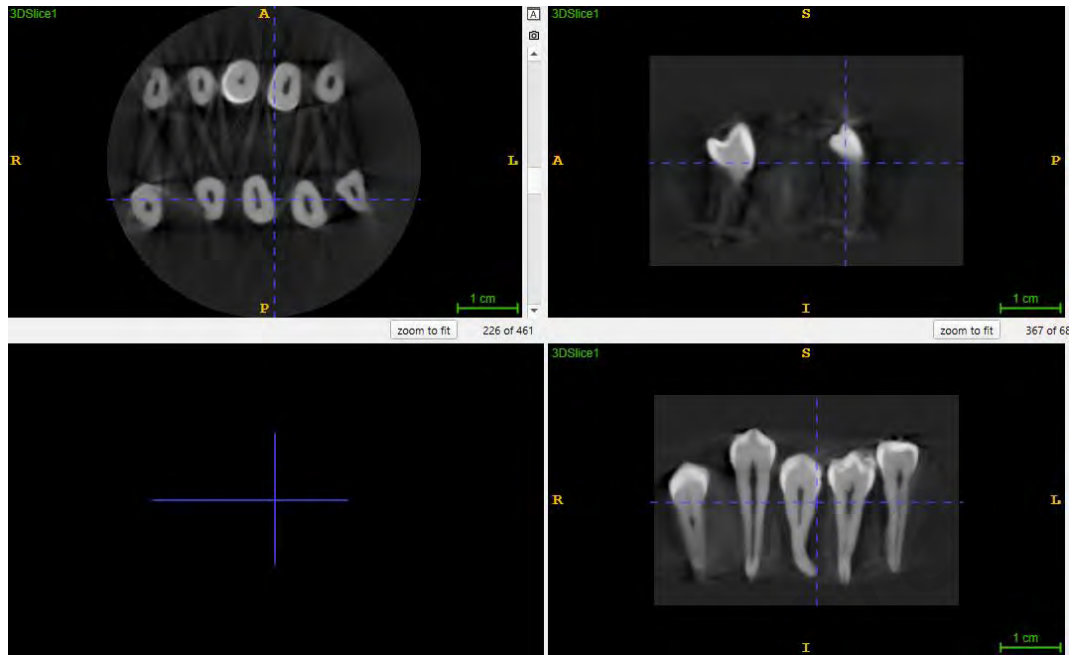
1: Example of CBCT image acquired from previous research project
